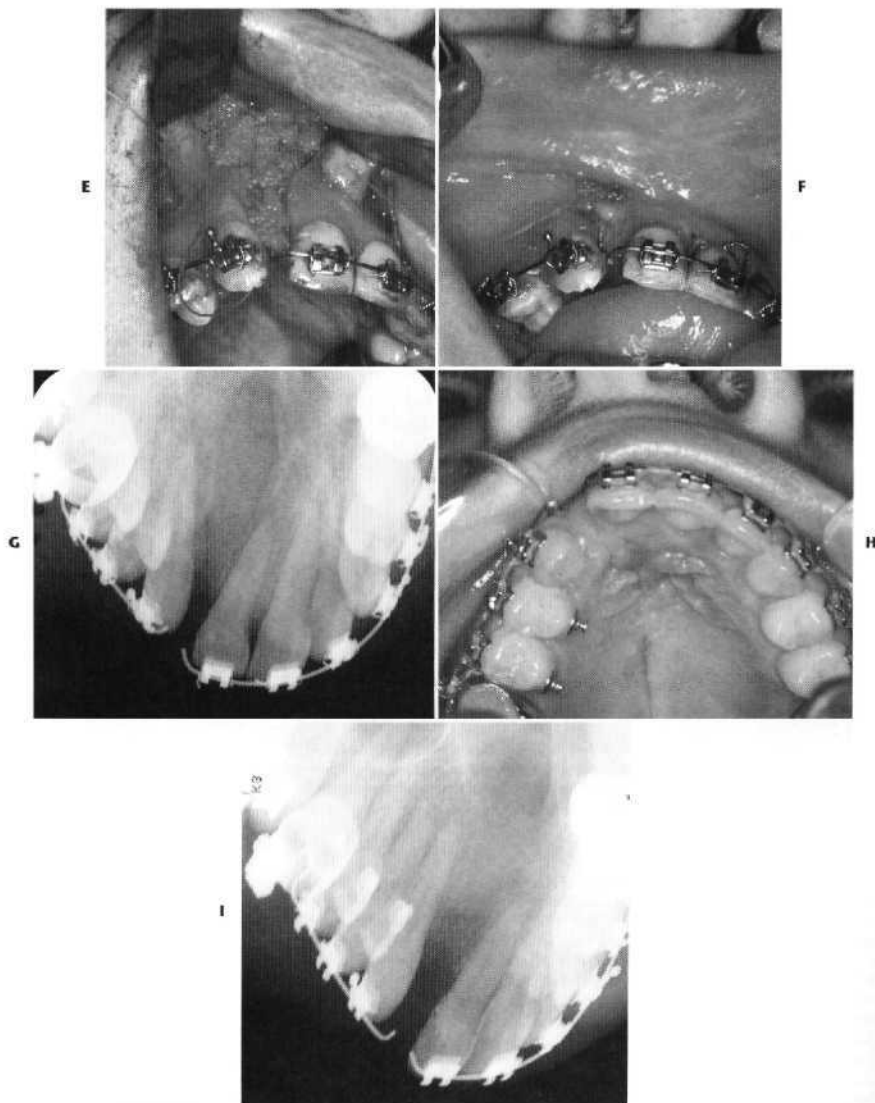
cont'd E, Particulate bone graft is placed into the defect. F, Closure of the palatal and labial mucosa over the bone graft. G, Radiographic result is demonstrated 3 days after surgery. H, Three months later the soft tissues have healed. I, Radiograph shows consolidation of the bone graft.
